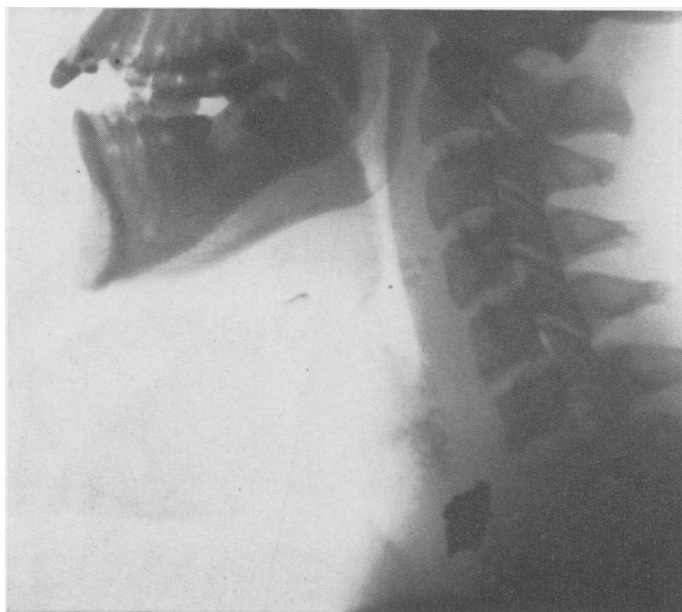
Lateral roentgenogram.
